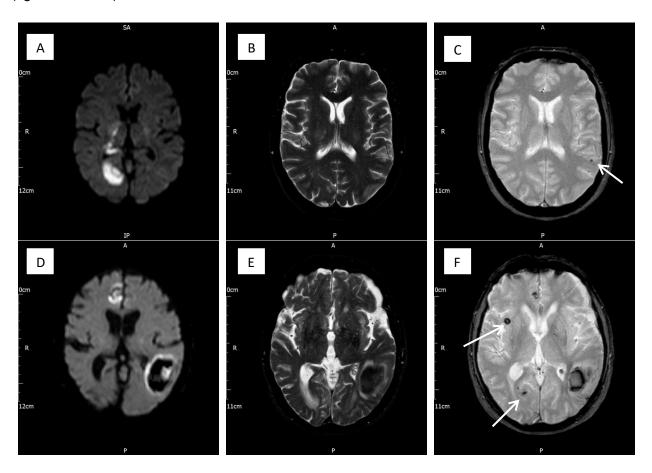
Example images from the stroke protocol performed at the study site. Images A & D- DWI, B & E, GRASE, C & F- T2*GRE. Images A to C- on a 46 year old female patient with a large area of restricted diffusion on the left side of the brain. CMBs present (arrow). Images D to F- 76 year old male patient with multiple haematomas seen throughout both cerebral hemispheres. Several CMBs seen (arrows). CMBs only deliniated on T2*GRE sequences.
